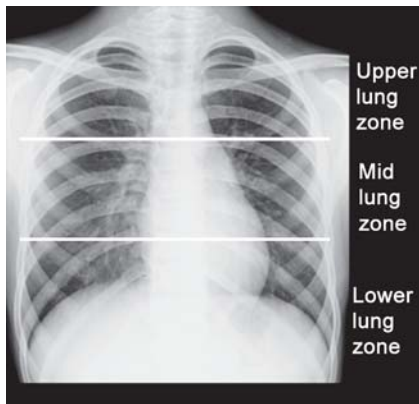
X-ray chest PA view shows the zones
